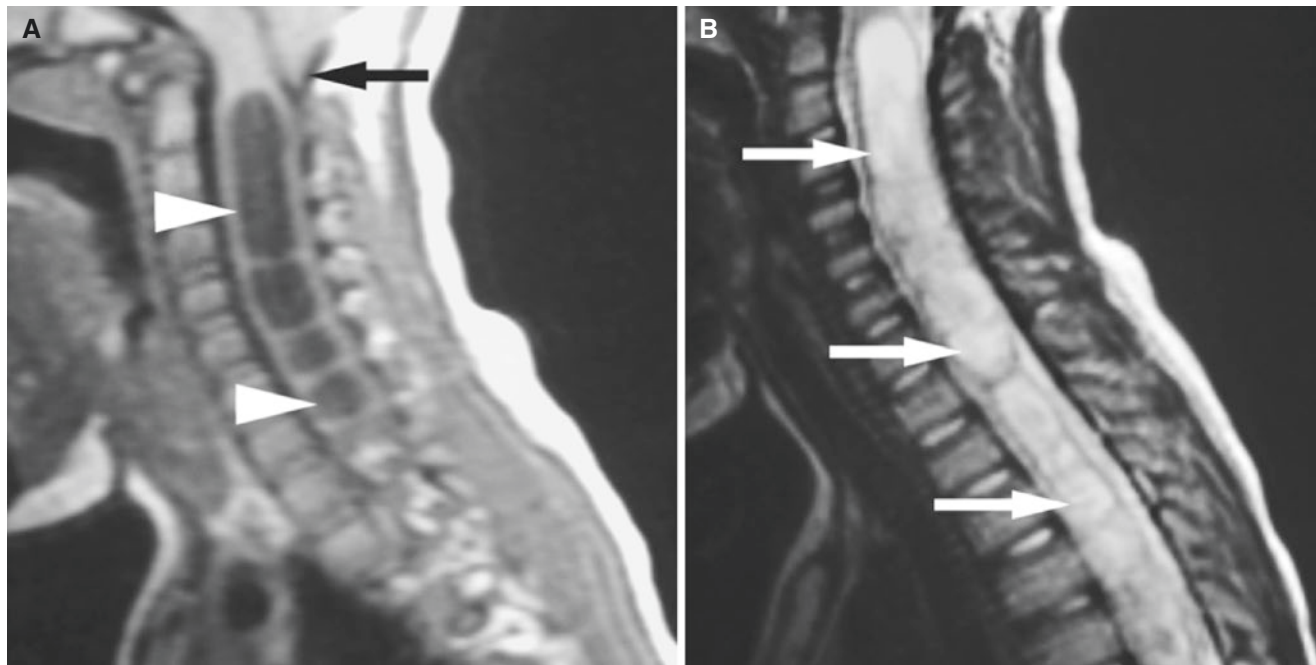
Chiari malformation type I; 5-year-old asymptomatic male. (A) Mid-sagittal T1-weighted MRI demonstrates caudal displacement of cerebellar tonsils (*arrow*). Dark signal in the center of cervical cord represents syringo- or hydromyelia with multiple locations (*arrow-*
